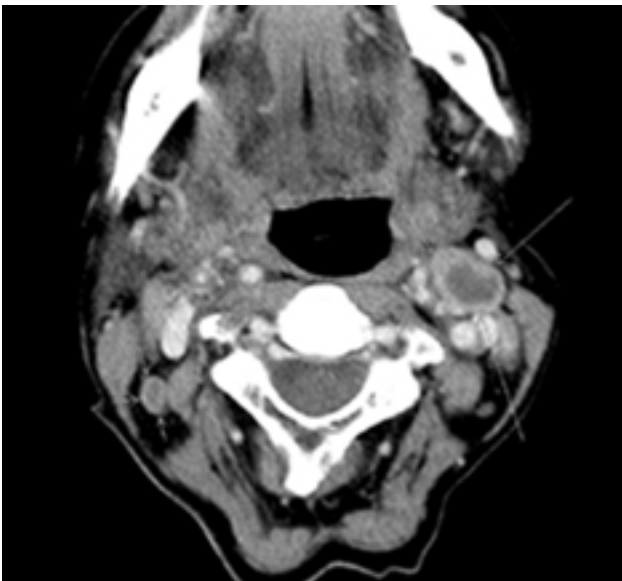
Computed tomography of the neck demonstrating a lymph node (18x14 mm) in anterior cervical triangle (big arrows). Note the central hypodensity and peripheral rim enhancement. Small arrows show another lymph node (8x5 mm) in the posterior cervical triangle
